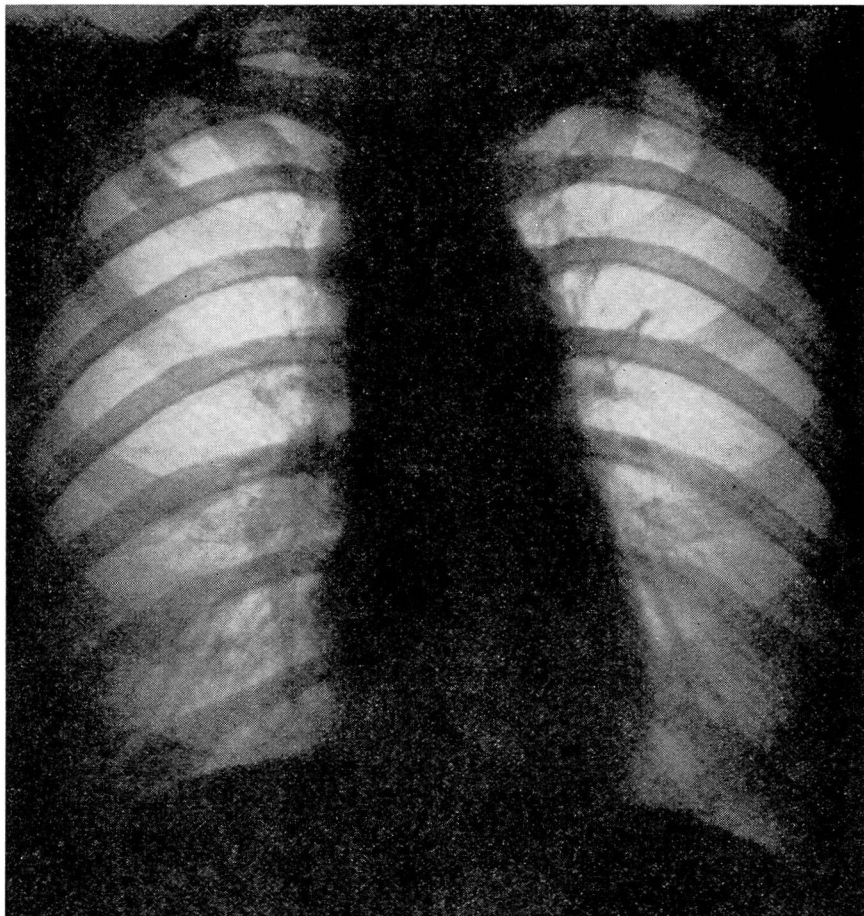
CASE 4: Same patient four years after roentgen therapy and now without evidence of the disease.
